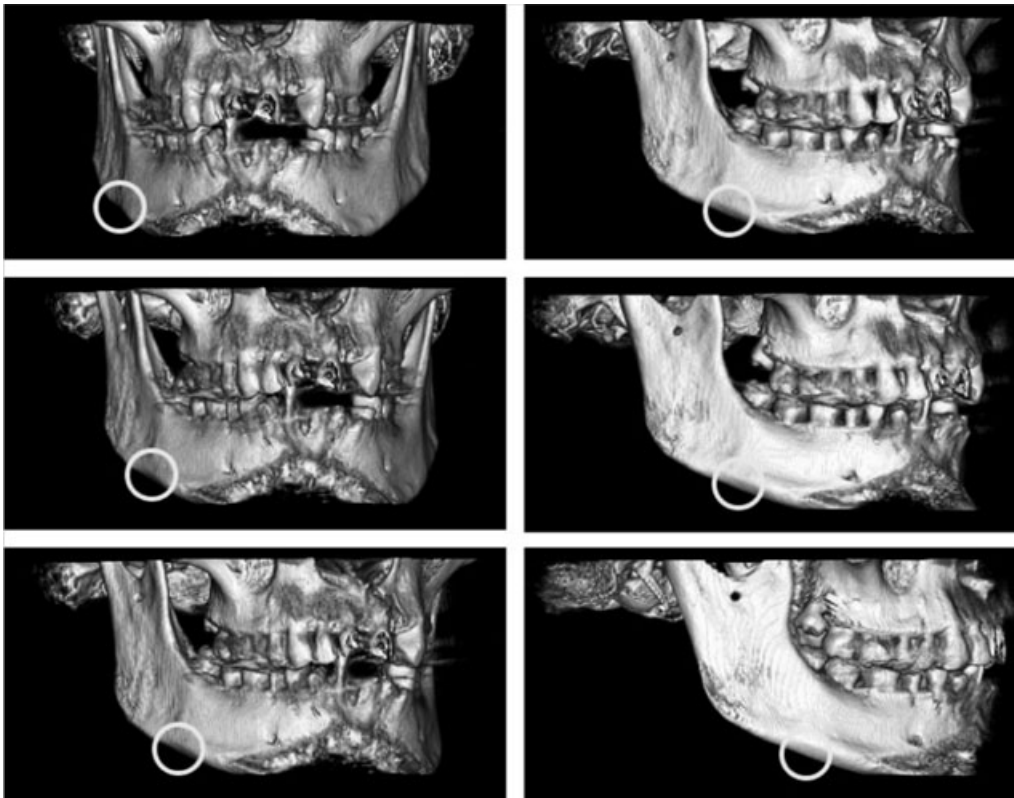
CBCT image of one of the skulls on which we were unable to obtain Ag values. The skull is rotating from the frontal view to the lateral view. The white circle highlights the landmark known as the right Ag on the frontal view as it rotates to its lateral position.
